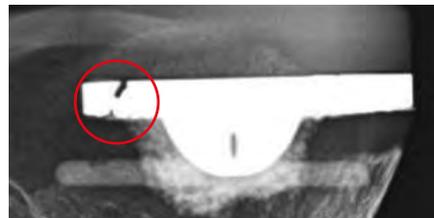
X-ray image of figure 3a
